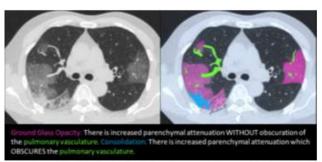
An axial-CT-scan Covid-19 patient, subpleural ground-glass opacities (GGO) and consolidation.
